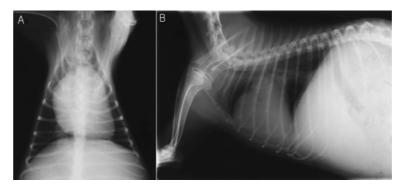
Thoracic radiography A: Dorsoventral projection of the radiography showed marked cardiomegaly with right ventricular enlargement. B: Lateral projection of the radiography showed increased cardiac sternal contact, a distension of the caudal vena cava, caudal gastric axis deviation, an enlarged hepatic shadow, and ascites. Marked dilation of the root of main pulmonary artery was also remarkable on this view.
